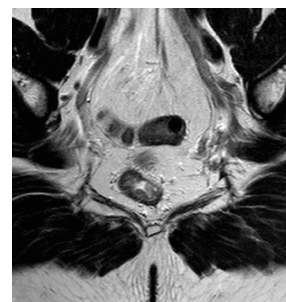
Forty-year-old man with LUTs and pain at sexual intercourse: Axial oblique T2-weighted double IR, Fat Sat and Dark Blood pulse sequence MR image showing hyperintensity signal from the right pudendal nerve along the Alcock's canal tenity of right pudendal nerve
